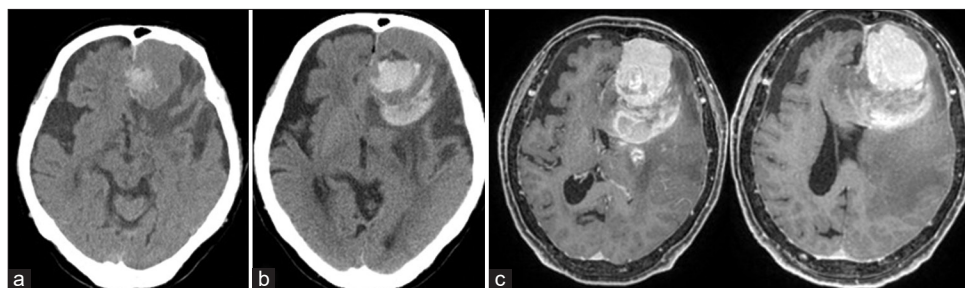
Postoperative day 26 computed tomography (CT) showing intratumoral hemorrhage (a). Postoperative day 48 CT showing intra and peritumoral hemorrhage (b). Gadolinium-enhanced T1-weighted image on MRI showing a diffuse enhanced tumor with an intratumoral hemorrhage and peritumoral hemorrhage compressing the surrounding brain (c).
